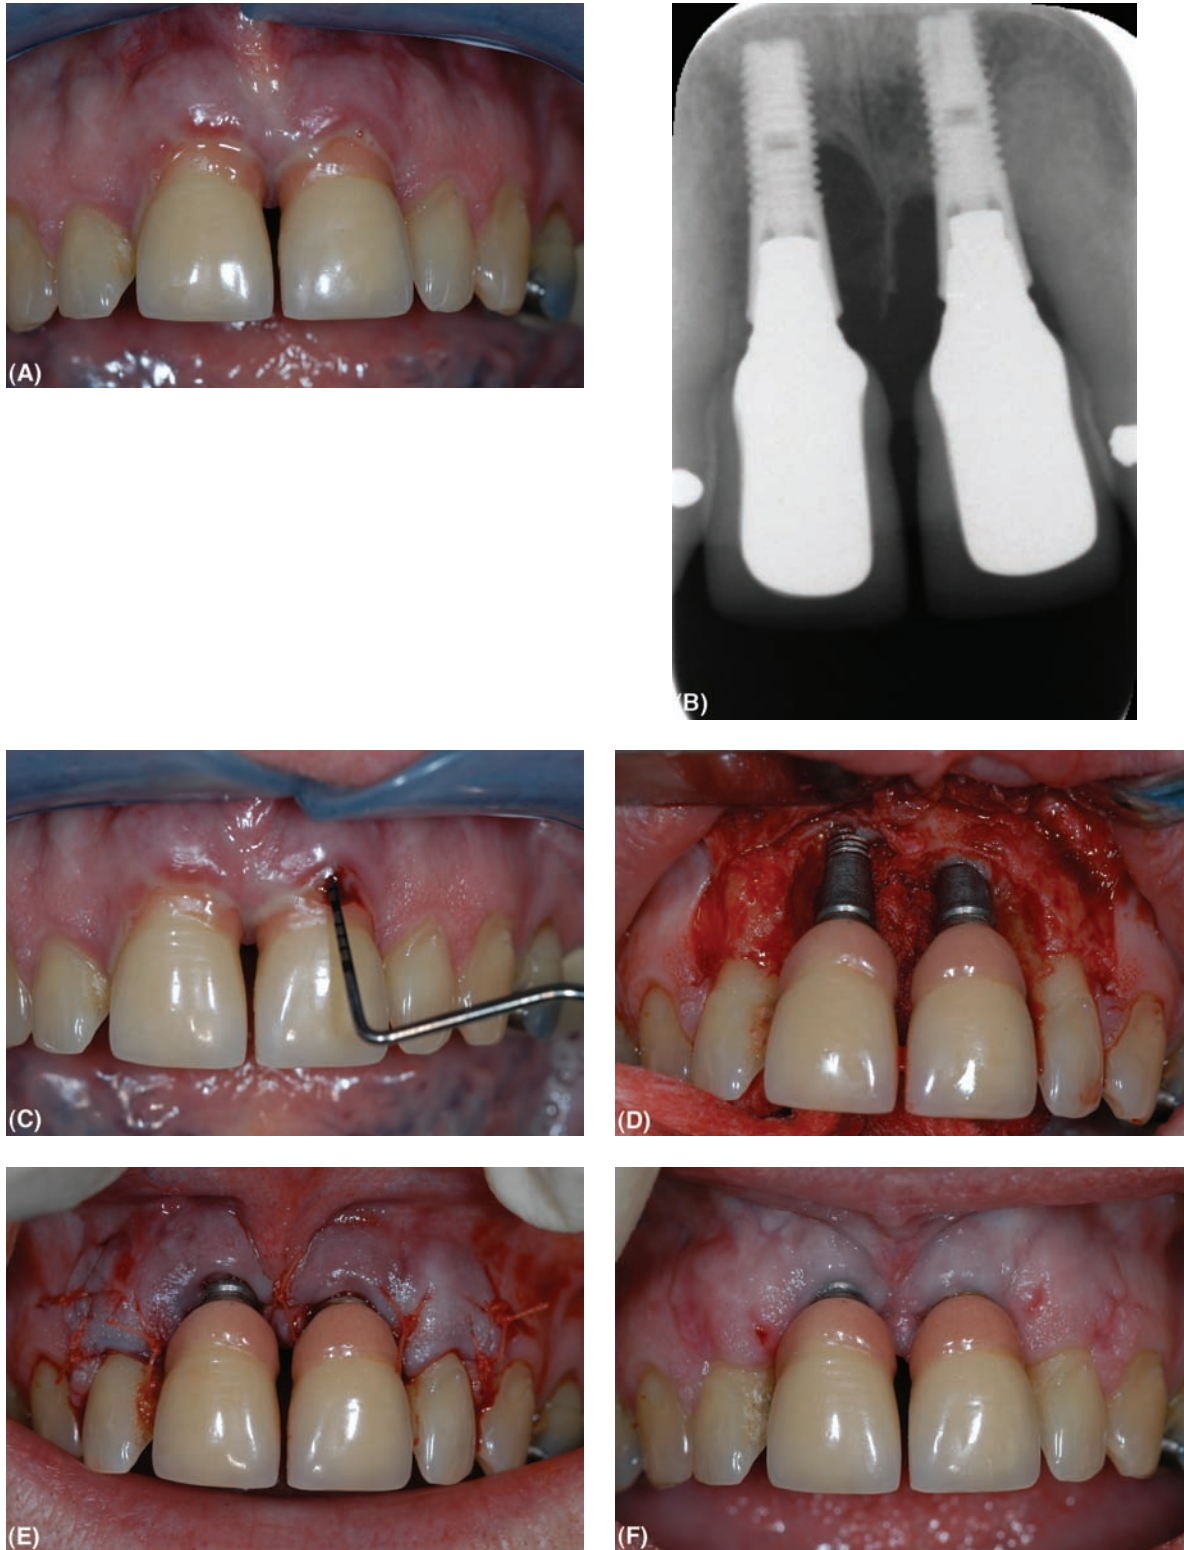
A series of photographs showing peri-implants affecting central incisor implants. (A) Both central incisors are implant-supported crowns. The patient has noticed swelling and discharge. The patient is a diabetic and has been poorly controlled. The implants were provided four years before. (B) The bone levels are at the top of the implant. Periodontal probing confirms a depth of at least 8 mm with pus and blood discharging. (C) Intraoral radiograph shows extensive bone loss associated with both implants. On the right implant, the bone loss extends over 50% of the implant length and on the left implant, to the level of the first macrothread. The saucerized bone loss is consistent with the lesion of peri-implantitis. A thin bone spur exists in the midline. (D) Buccal and palatal flaps have been raised and the inflammatory tissue removed to show bone loss, consistent with the radiograph. Initial cleaning of the implant surfaces has begun. Excess glass ionomer cement was noted around the abutment and implant heads. (E) Following thorough debridement of the implant surfaces, the soft tissue has been positioned apical to the very bulbous crowns. (F) The healed result two weeks after the surgery. There has been some further shrinkage of the soft tissue margin but there is no obvious inflammation and no exudate.
